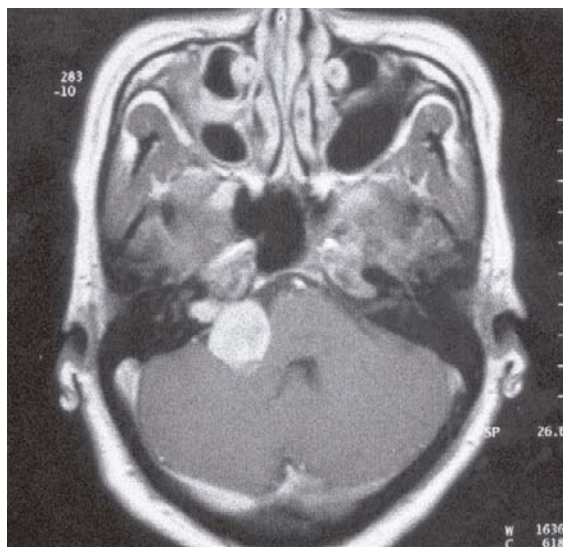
Enhanced axial T1-W MR image shows a heterogeneous extra-axial tumour in the right cerebellopontine angle.
